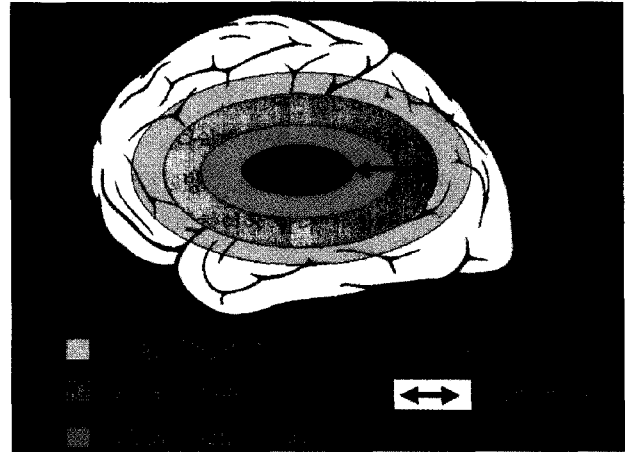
Modified view of MRI-defined ischemic penumbra in which the penumbra equals not only regions of diffusion-perfusion mismatch but also a portion of the diffusion abnormality itself. (From ref. 72)
